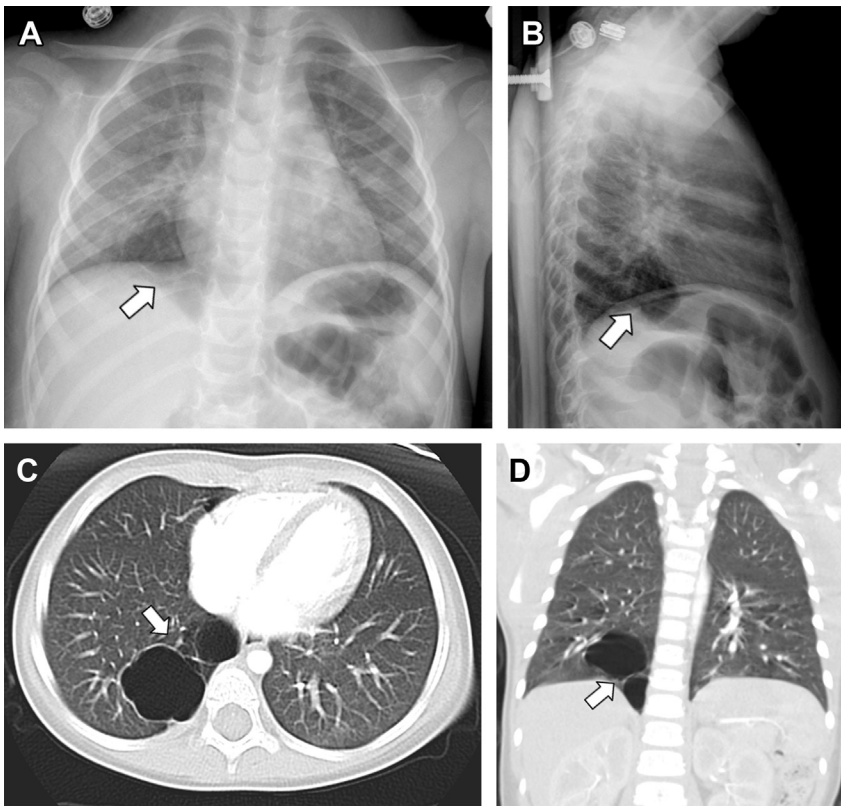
A 2-year-old-boy with type 1 congenital pulmonary airway malformation (CPAM). Frontal (A) and lateral (B) chest radiographs demonstrate an air-filled multicystic lesion (arrows) in the right lower lobe. Axial (C) and coronal (D) lung window CT images show the lesion (arrows) is composed of multiple large air-filled cysts.
